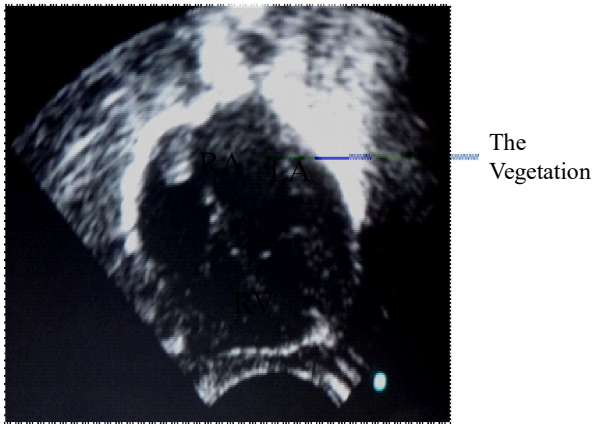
Echocardiographic findings of an atrial thrombus
